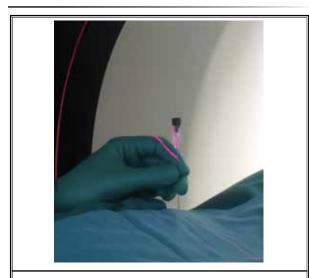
Operating within the CT gantry. Most spinal pain interventional procedures can be performed by operating within the CT gantry. This reduces patient motion during table movement and overall procedural time.
